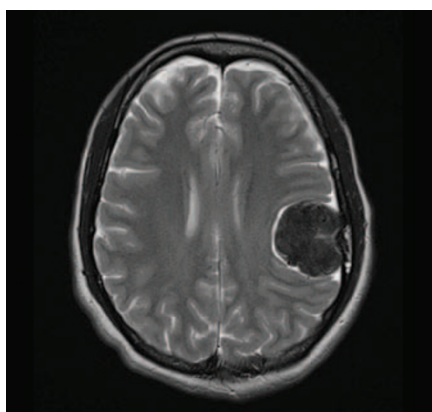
An MRI indicating the cranial lesion
